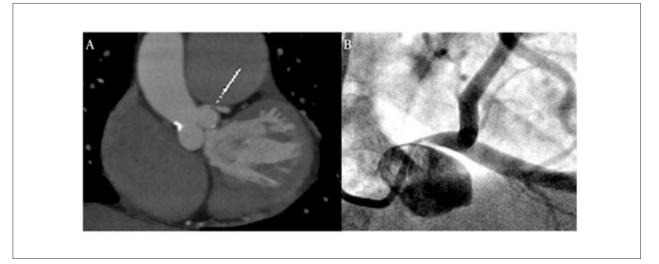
A*) Computed tomography angiography showing inferior displacement of the left main coronary artery caused by an aneurysm of the pulmonary artery and left coronary ostial stenosis. B) coronary cineangiography of the same patient, showing occlusion of the left main coronary artery ostium.
